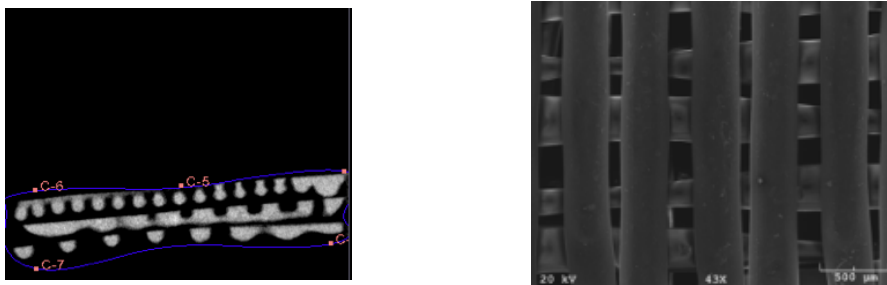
Micro-computed tomography (left) and SEM (right) images of a 3D printed scaffold. The image on the left was taken during the reconstruction process using 3D Slicer.
